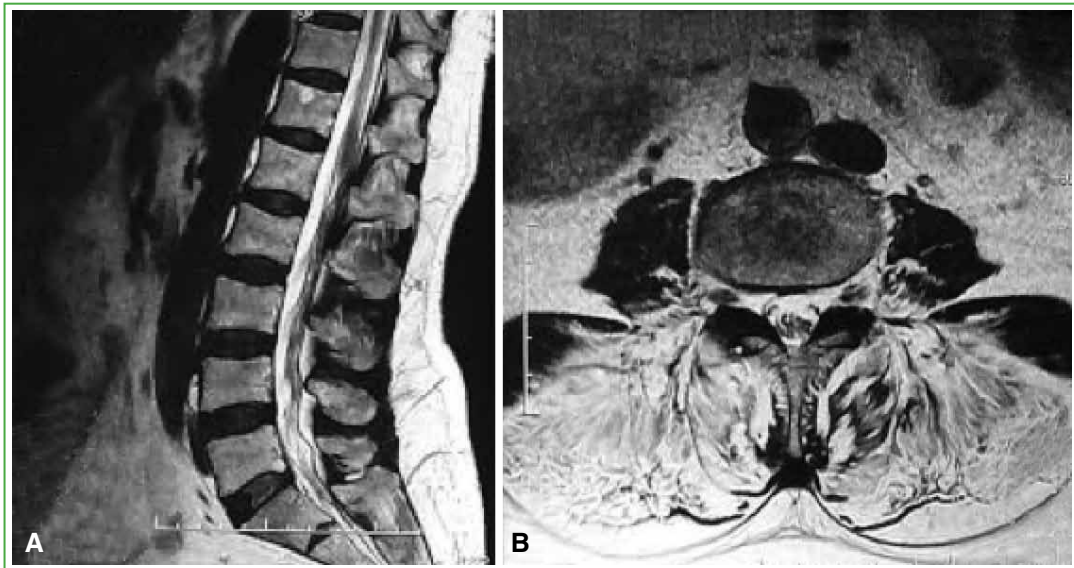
Preoperative MRI. A. In the sagittal section, no structural condition can be seen. B. Transverse section of T2 showing significant fatty replacement of the paraspinal erector muscles.
